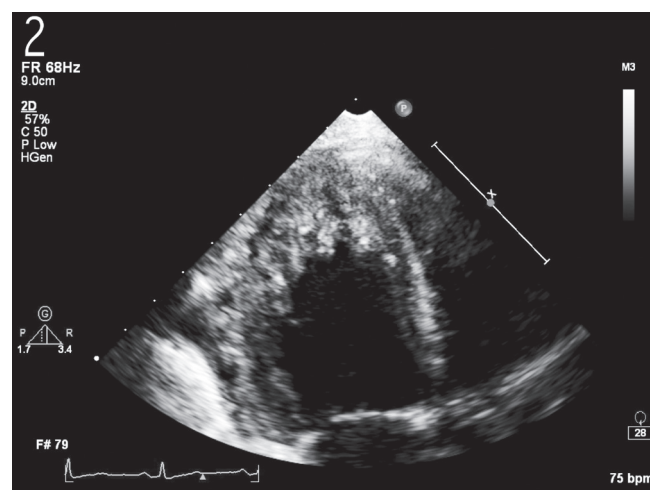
Apical two-chamber view in end-systole demonstrating the marked trabeculation of the apex and apico-inferior wall with the underlying thin epicardial compacted area.
